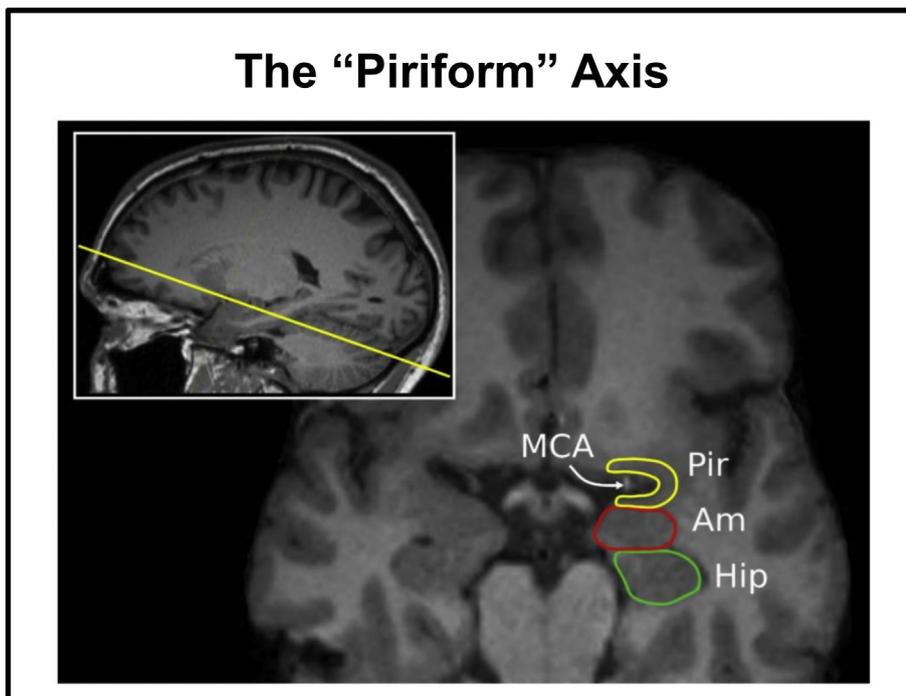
T1-weighted MPRAGE image of a healthy adult male, displayed in para-sagittal (small image) and oblique-axial orientation (large image), approximately +20° relative to the anterior commissure-posterior commissure axis. Pir = piriform cortex, Am = amygdala, Hip = hippocampus. The arrow indicates the location of the middle cerebral artery (MCA) within the entorhinal sulcus. Fig. 5 reproduced from Vaughan and Jackson (2014).
